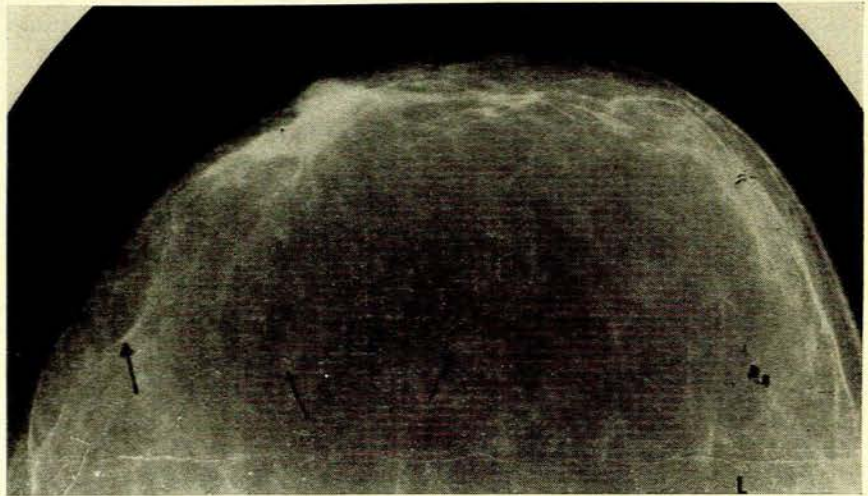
Clinically, cystic changes were felt in the left breast. (Right mastectomy had been performed 1 year previously.) Some generalized nodularity. X-ray showed no evidence of malignancy. Note trabeculae coursing around translucent masses—most probably lipomata.
